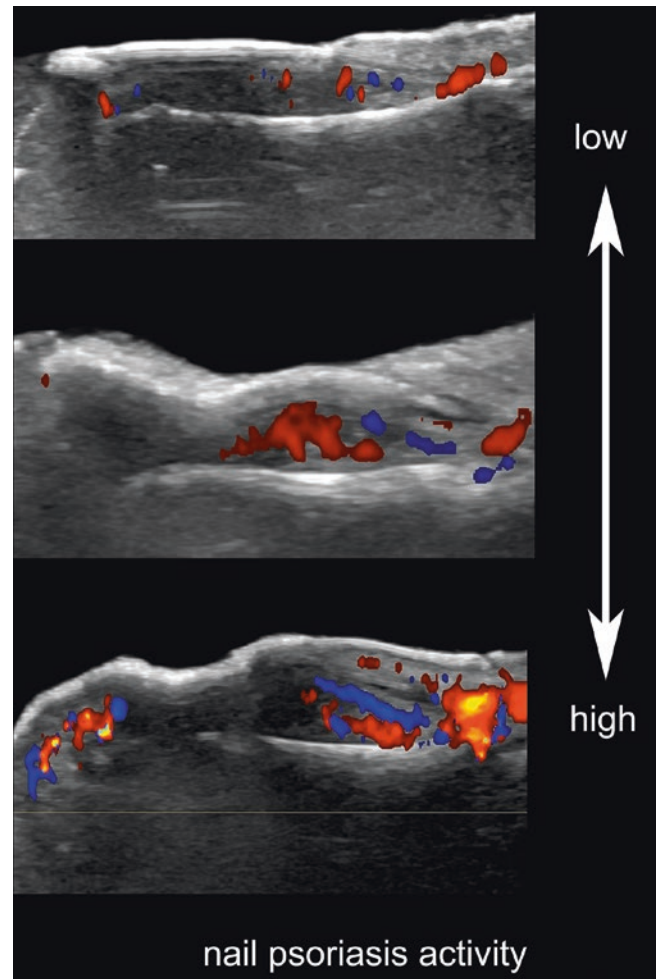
Color Doppler ultrasound grading of activity in nail psoriasis.
